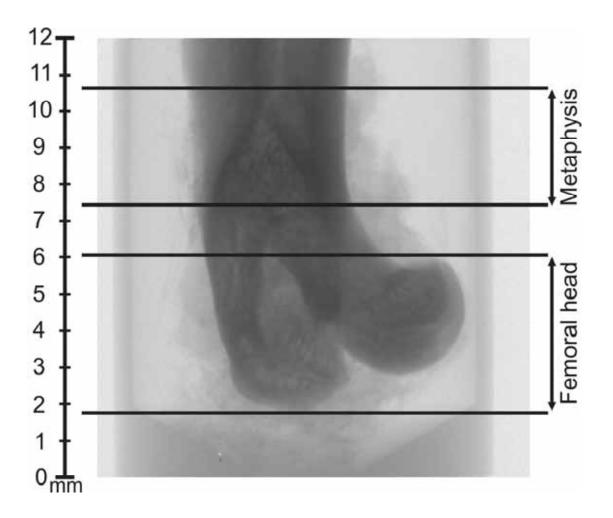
A typical μ CT-scan image. Areas for the separate data-sets of femoral head and metaphysis are depicted.
